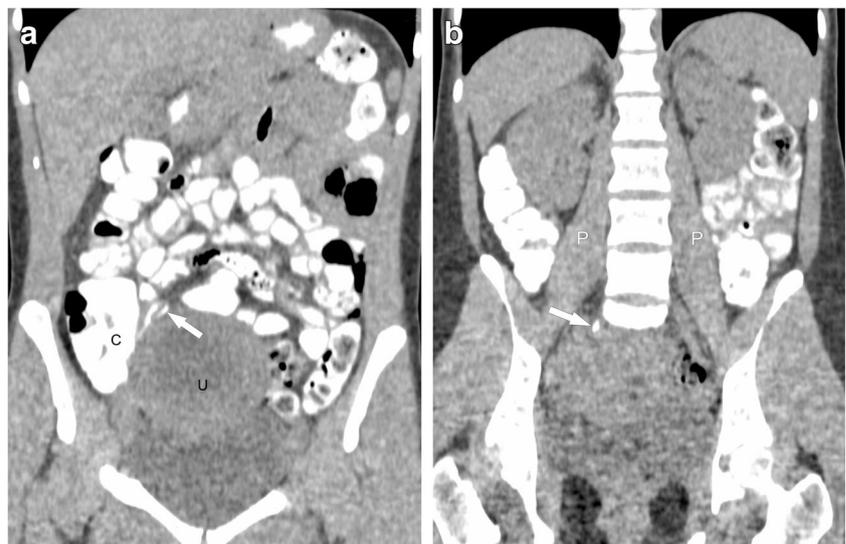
A 22-year-old pregnant woman (10 weeks), right lower quadrant pain. Admission US was reported indeterminate for appendicitis. a Low-dose CT with oral contrast shows a normal appendix (*arrow*), situated between the caecum (*C*) and the pregnant uterus (*U*). b Low-dose CT
